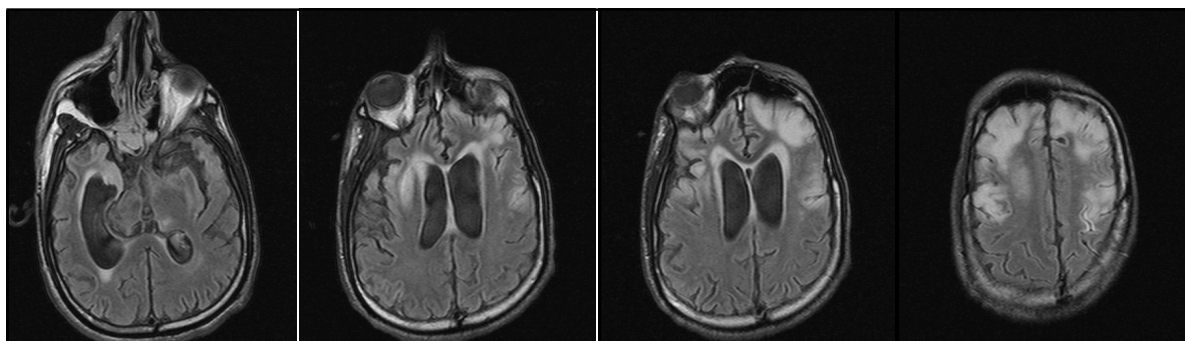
FLAIR Axial Images Show Marked Cortical Atrophy & Volume Loss With Increased Signal Intensity of Cortical & Deep Grey Matter
